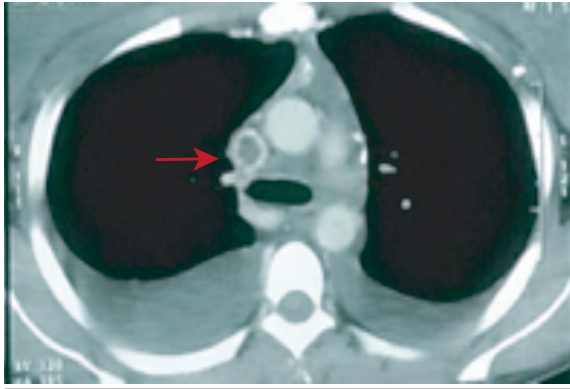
Contrast-enhanced computed tomography thorax showing superior vena cava thrombus.
